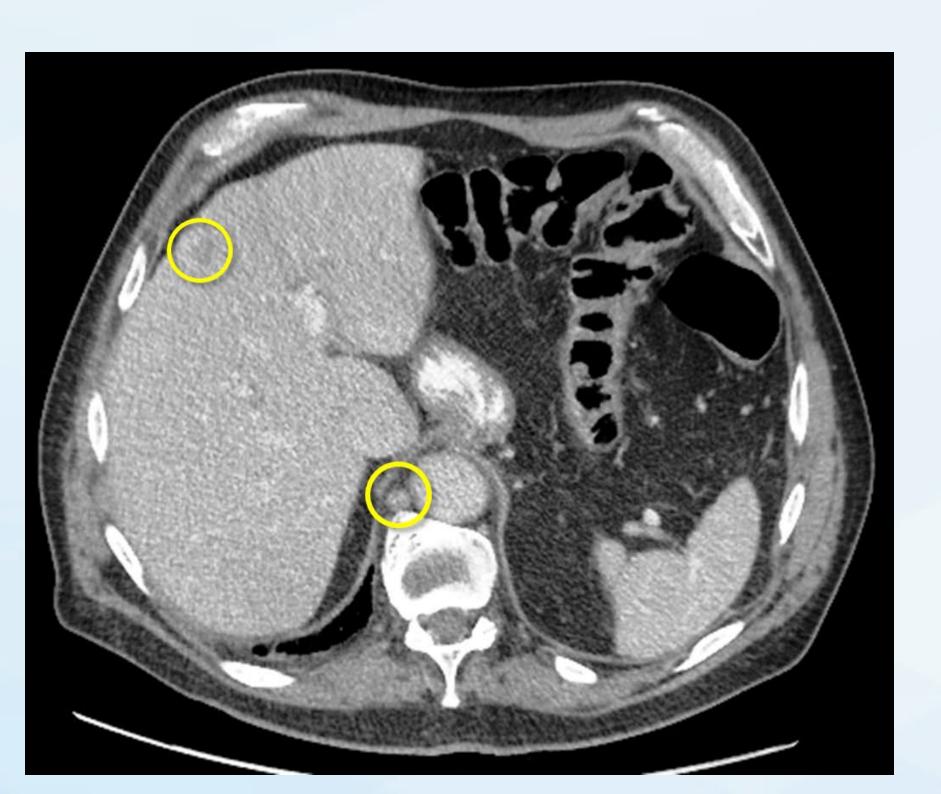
Routine follow up CT abdomen status post esophagectomy 4 months prior showing a hypodense liver lesion with increasing para-aortic lymphadenopathy.
